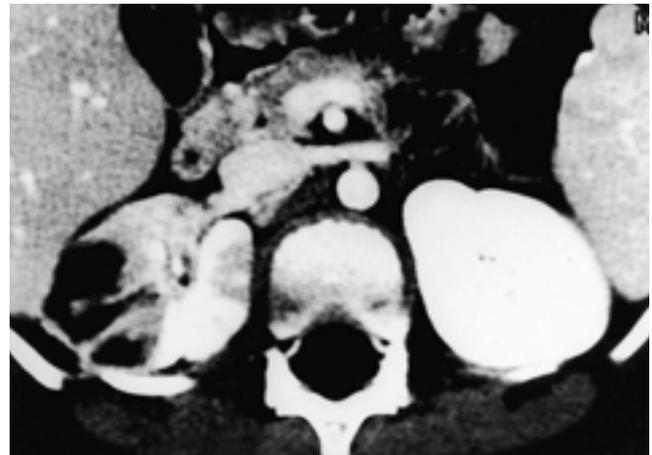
CT pattern IIIB in a 7 year-old-boy who had fever for 5 days with 39.4 , and 21days of admission periods. Postcontrast CT shows multiple linear and wedge hypoenhancing lesions with abscess formation in the right kidney.
